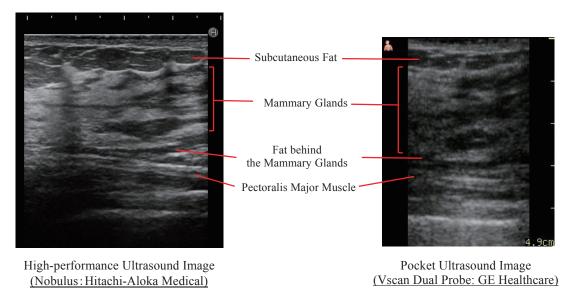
Comparison of pocket ultrasound image and high-performance ultrasound image in the breast
